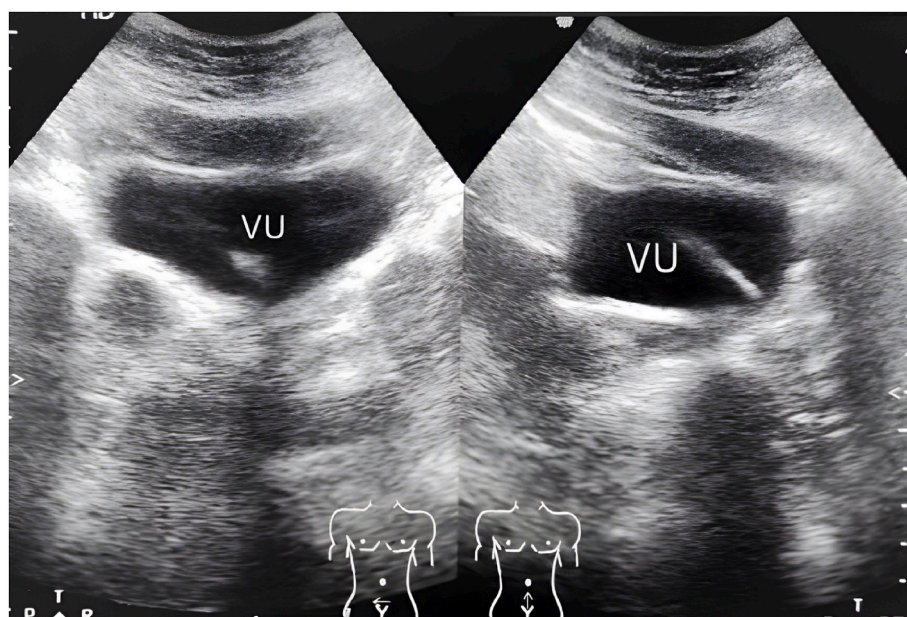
Ultrasonographic in transverse and longitudinal views showing a hyperechoic lesion in the bladder.
